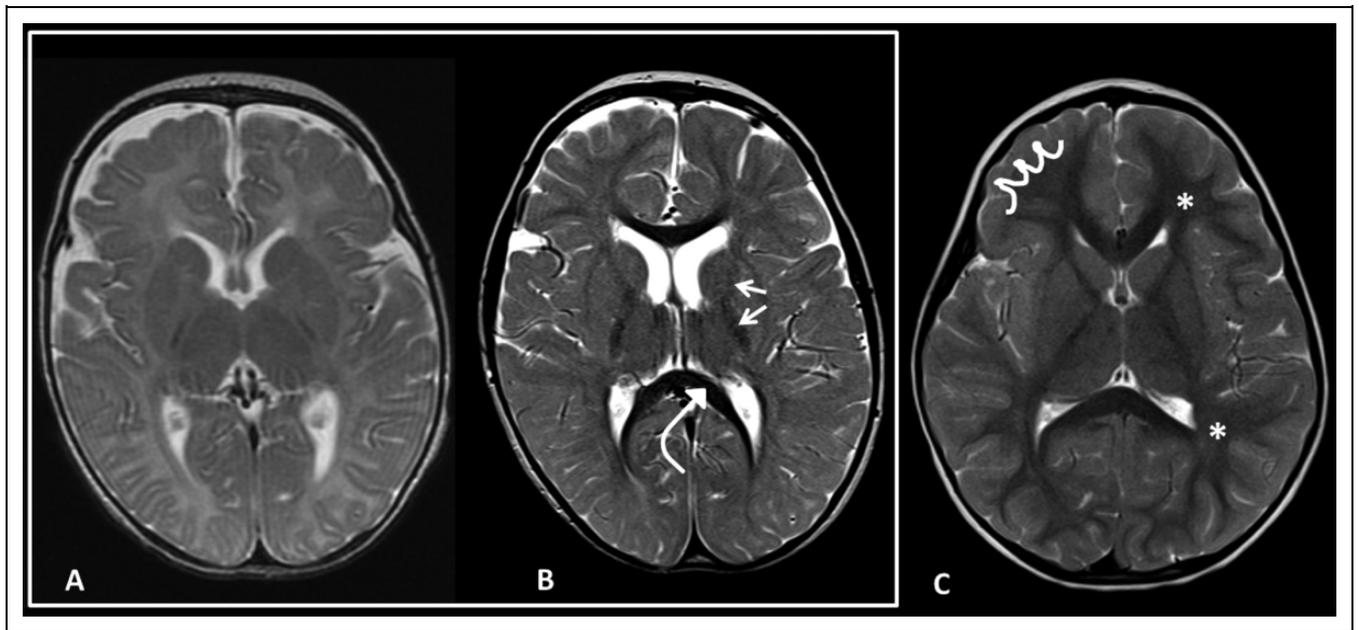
T2-weighted MRI images from Patient 1 with X-linked monocarboxylate transporter 8 deficiency at 8 months of age (A) and 6 years of age (B) in comparison to a normal 6-year-old control patient (C). Note that corpus callosum (curved arrow) and cortical spinal tracts (arrows) show progressive myelination and almost normal appearance when compared to control. The (*) and curved lines on (C) show the normal pattern of the white matter and U-fiber, which are poorly defined in X-linked monocarboxylate transporter 8 deficiency (B).
